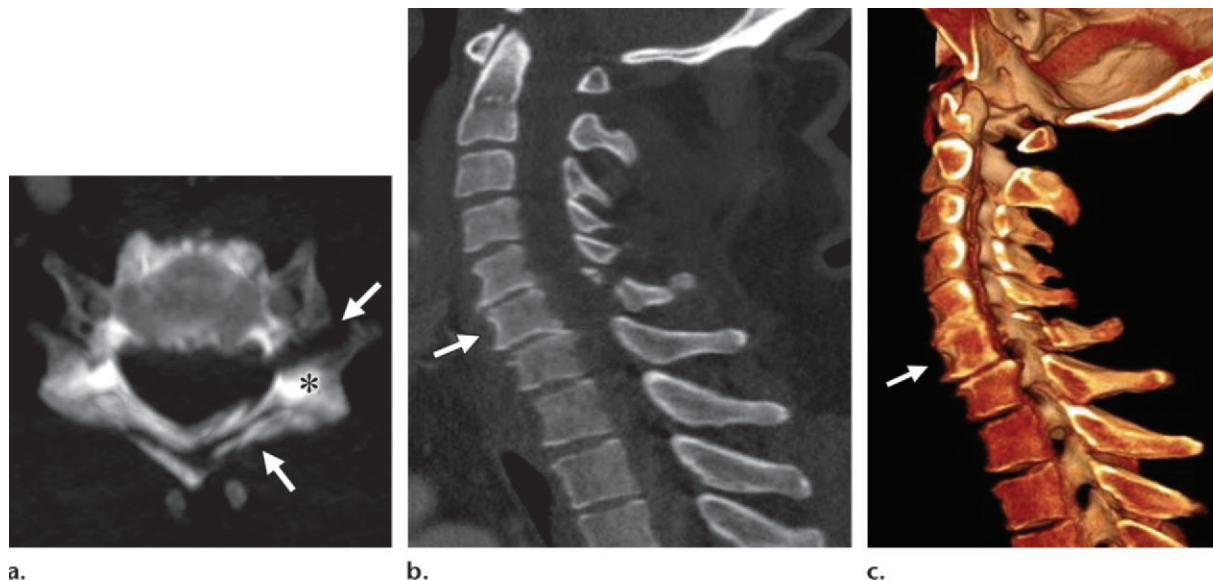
Translation injuries: rotation-translation injury in a 61-year-old patient who was an unrestrained driver in an MVC. (a) Axial MIP image shows left C6 pedicle and lamina fractures (arrows), with separation of the lateral mass (*). (b) Multiplanar reformatted CT image through the midsagittal plane of the spine below the injured segment shows off-center spinous processes of C2 through C6 (arrow). (c) Sagittal half-space slab volume-rendered CT image shows less than 50% anterior translation of the C6 vertebral body, with rotated vertebral bodies at and above the injured level (arrow).
